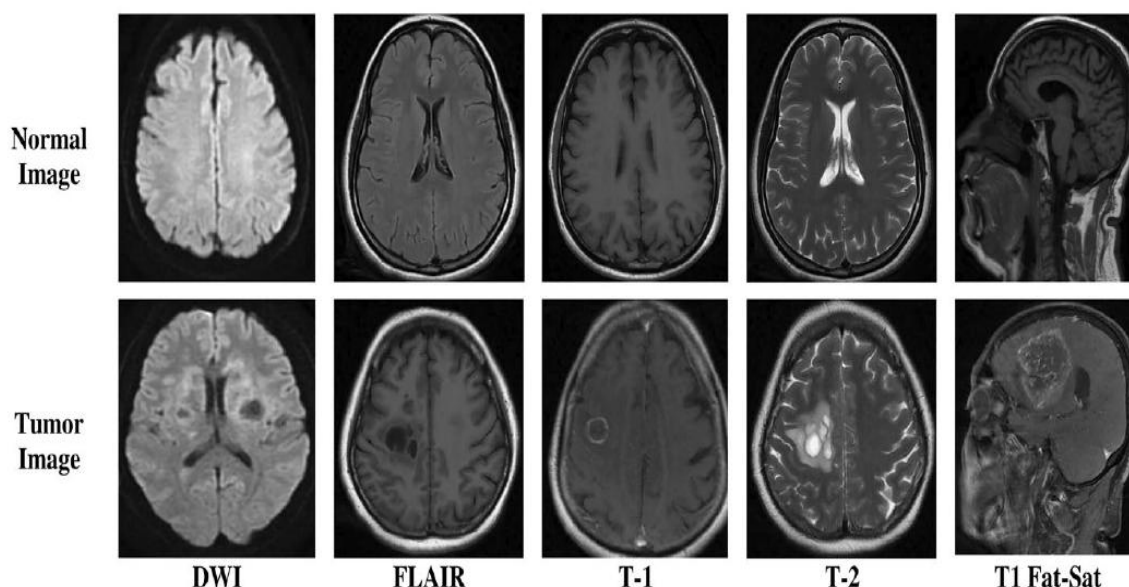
Brain MRI Segmentation with and without Tumor
